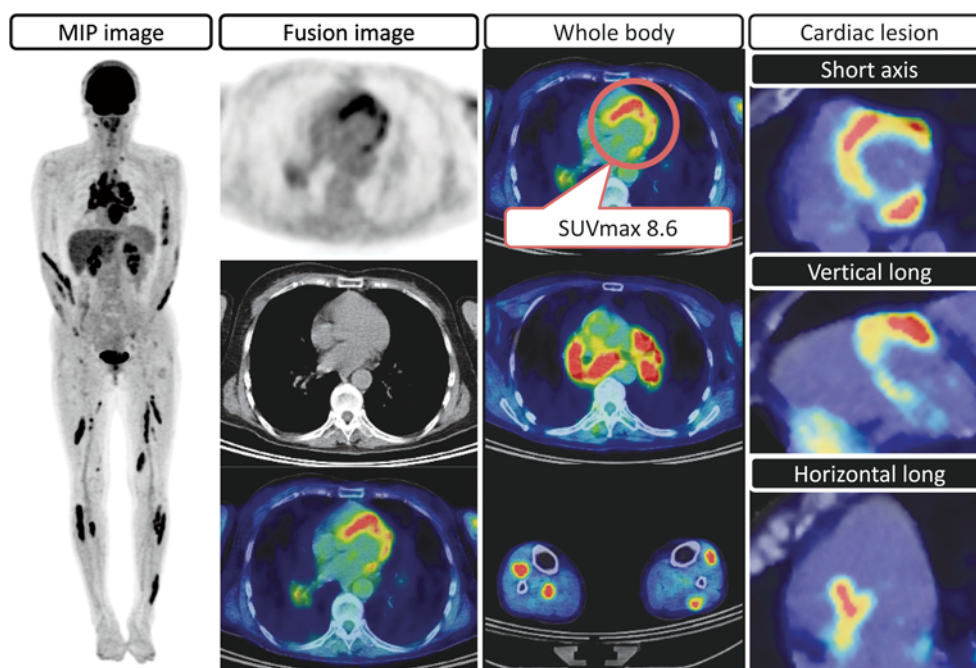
Standard approach to interpretation of fasting ¹⁸F-FDG PET/CT images
